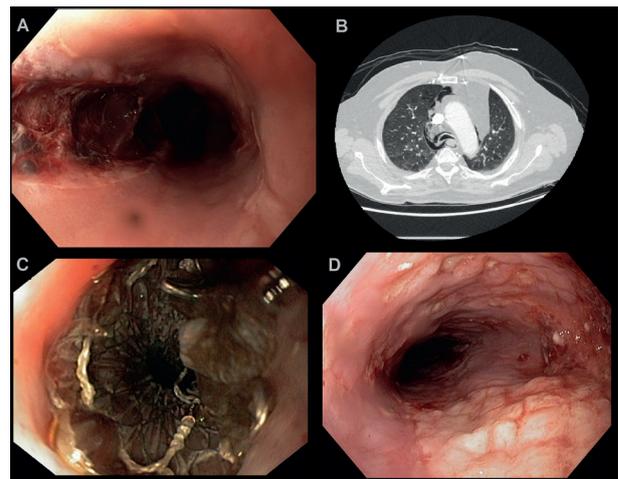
A. Multiple lacerations in the esophagus during endoscopy on admission. B. CT scan on admission : pneumomediastinum. C. An endoscopic esophageal stent was placed. D. Upper endoscopy after stent removal, a pressure ulcer in the distal esophagus was seen.
